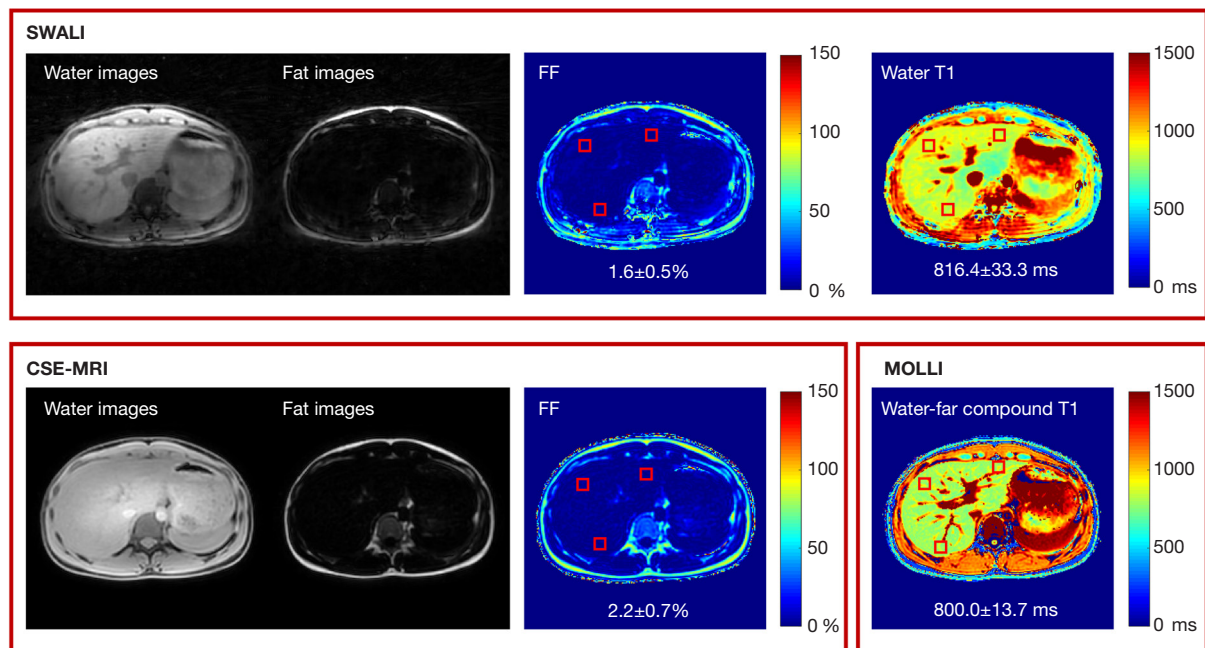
Quantitative mapping results of 1 healthy volunteer (female, 28 years old). The separated water image, fat image, FF map, and water T1 map estimated by the proposed SWALI sequence are compared with the separated water image, fat image, and FF map estimated using the CSE-MRI sequence and the water-fat compound T1 estimated using the MOLLI sequence. The red squares show 3 ROIs ($\sim 100 \text{ mm}^2$ each) that were manually drawn. The mean FF and water T1 were calculated within each ROI. SWALI, simultaneous water-fat separation and T1 mapping of the whole liver; FF, fat fraction; CSE-MRI, chemical shift-encoded magnetic resonance imaging; MOLLI, modified Look-Locker inversion recovery; ROI, region of interest.
